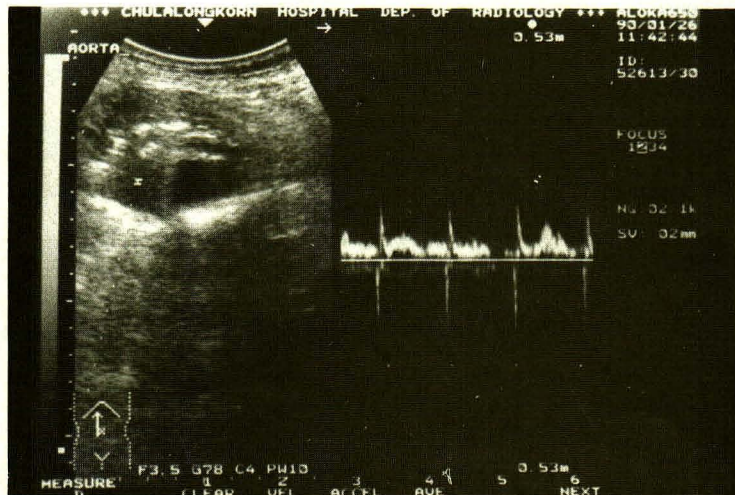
Doppler study near the aortic wall defect showing turbulent flow from the anterior lumen into the posterior space.
